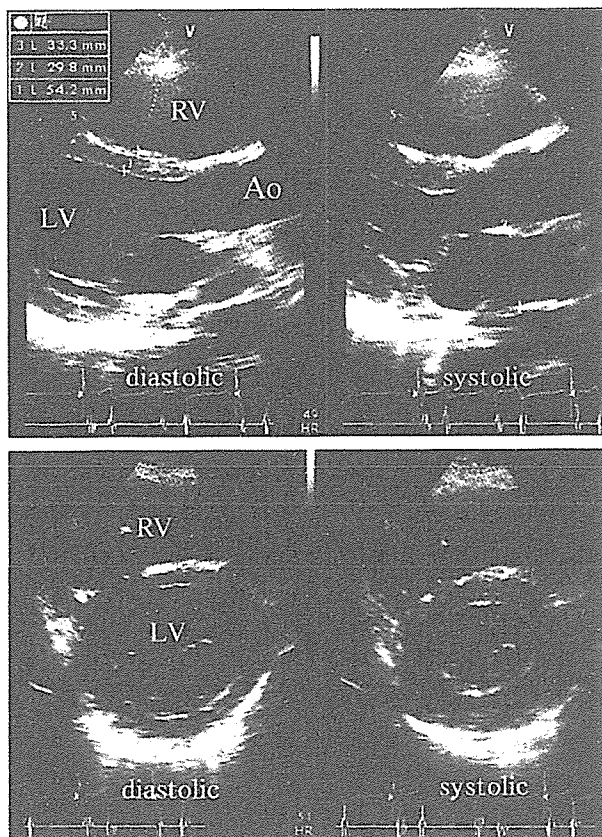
Echocardiography revealed an enlarged, hypokinetic right ventricle (RV) with a paper-thin free wall. LV, left ventricle; Ao, ascending aorta.
